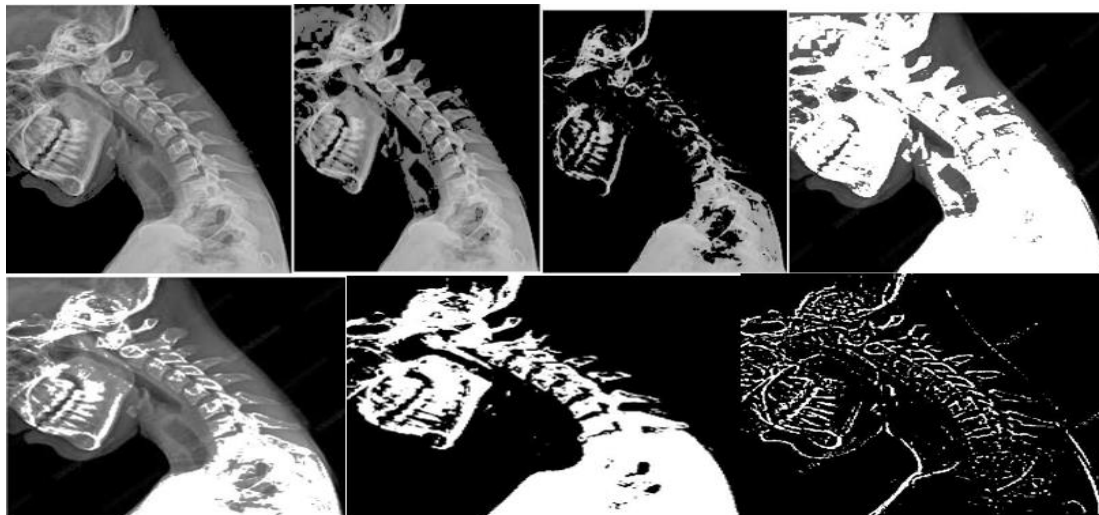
(a): neck radiograph basic thresholding; from left, threshold image with black reduced to 20%, threshold image with black reduced to 40%, threshold image with black reduced to 60%, threshold image with white reduced to 40%, threshold image with white reduced to 60%, threshold image with black and white reduced to 50% each and adapted threshold image
